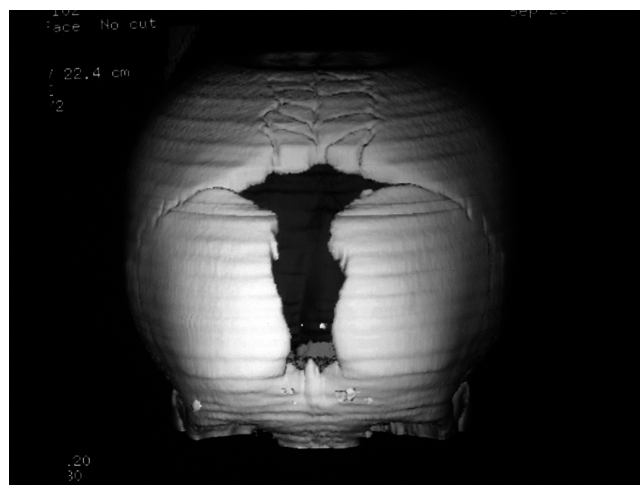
3D CT scan of skull, clearly delineating the open frontanelle and multiple wormian bones.
